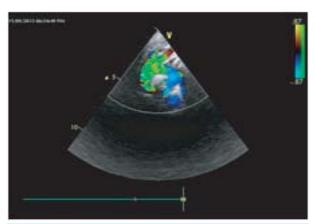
(c) Colour Doppler showing Coanda effect
